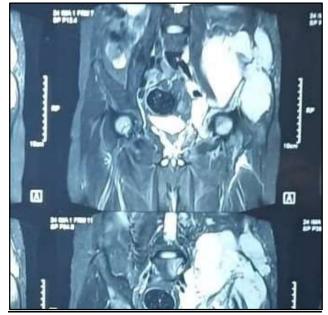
Section of CT scan showing tumor size.
